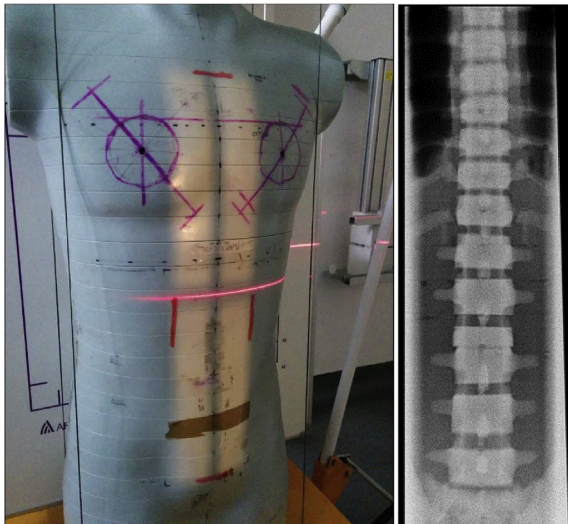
Photograph and radiograph showing extents of tight collimation.
